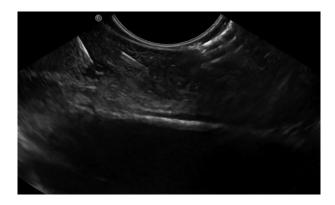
Endosonography highlighting correct placement of 2 fiducials within the submucosal layer.
